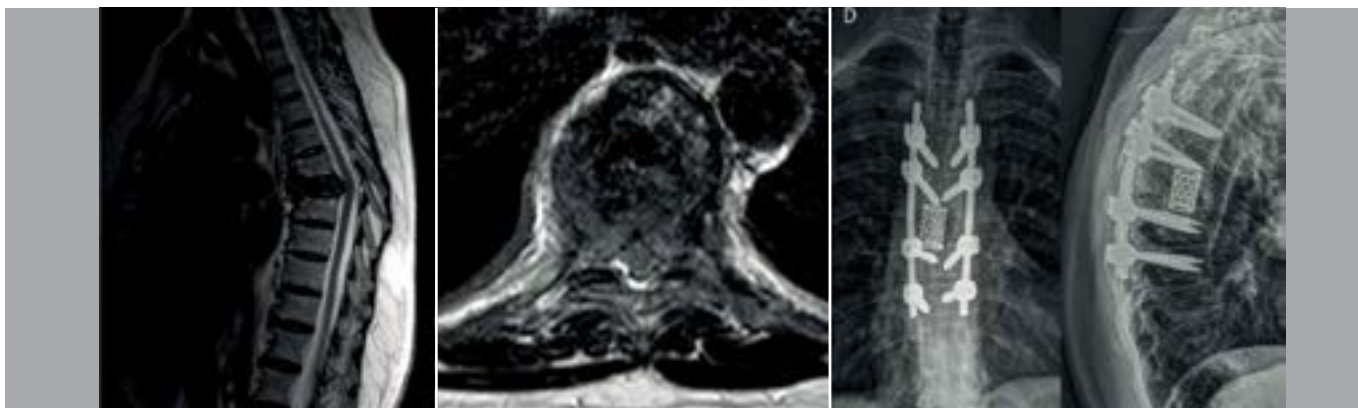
Sagittal and axial cuts of T2-weighted preoperative magnetic resonance showing metastatic assailment of the T7 vertebral body and spinal compression. Postoperative radiographies of decompression and posterior fixation with pedicular screws associated with corpectomy and replacement with intersomatic device filled with bone cement.
